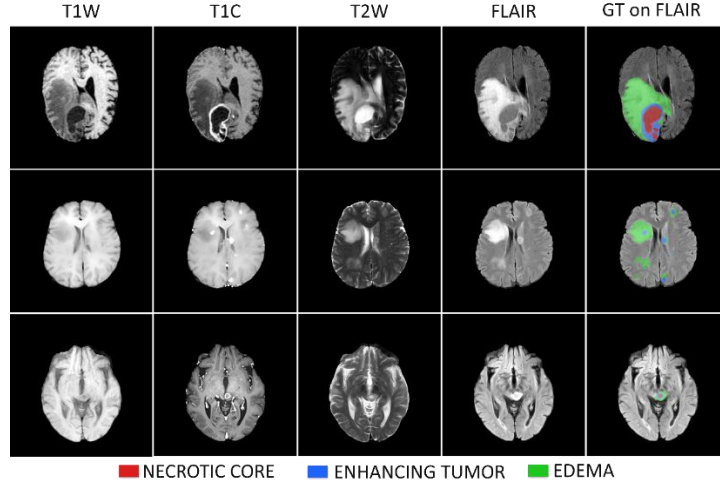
Three training cases from data, shown as the four MRI channels with reference overlaid on FLAIR in the last column. Row 1, row 2 and row 3 show a large single mass, a multifocal case, and a small mainly enhancing lesion, respectively. Enhancing
